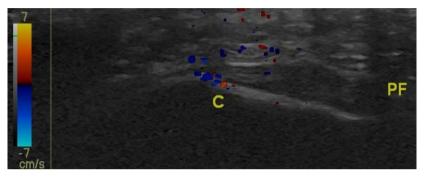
Colour Doppler showing increased vascularity at the proximal end of an abnormally thickened hypoechoic plantar fascia.
